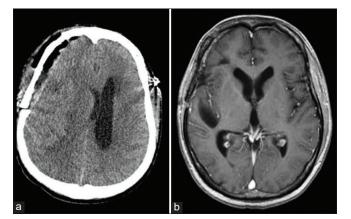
Immediate postoperative computed tomography scan showing total removal of tumor with some certain extent of midline shift (a). Magnetic resonance imaging axial T1-contrast scan 6 months after operation showing no recurrence (b).
